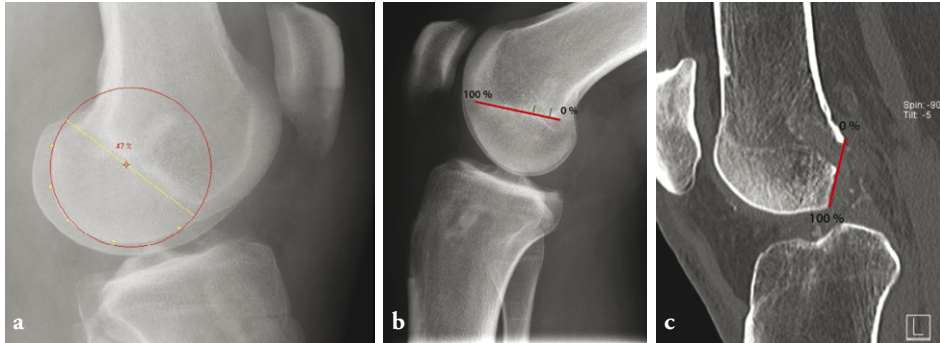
Lateral view of the lateral femurcondyle with the method of Amis. The yellow dots are the user-defined edges of the posterior femoral condyle. A circle is automatically fitted on to the dots and can be rotated, in such a way that the diameter is parallel with Blumensaat’s line. b. Lateral view of the lateral femurcondyle with the method of Aglietti. Aglietti compares the tunnel measurement with a line parallel to the most posterior and anterior part of Blumensaat’s line. c. Measurement according to Aglietti on the sagittal femoral CT reconstruction.
